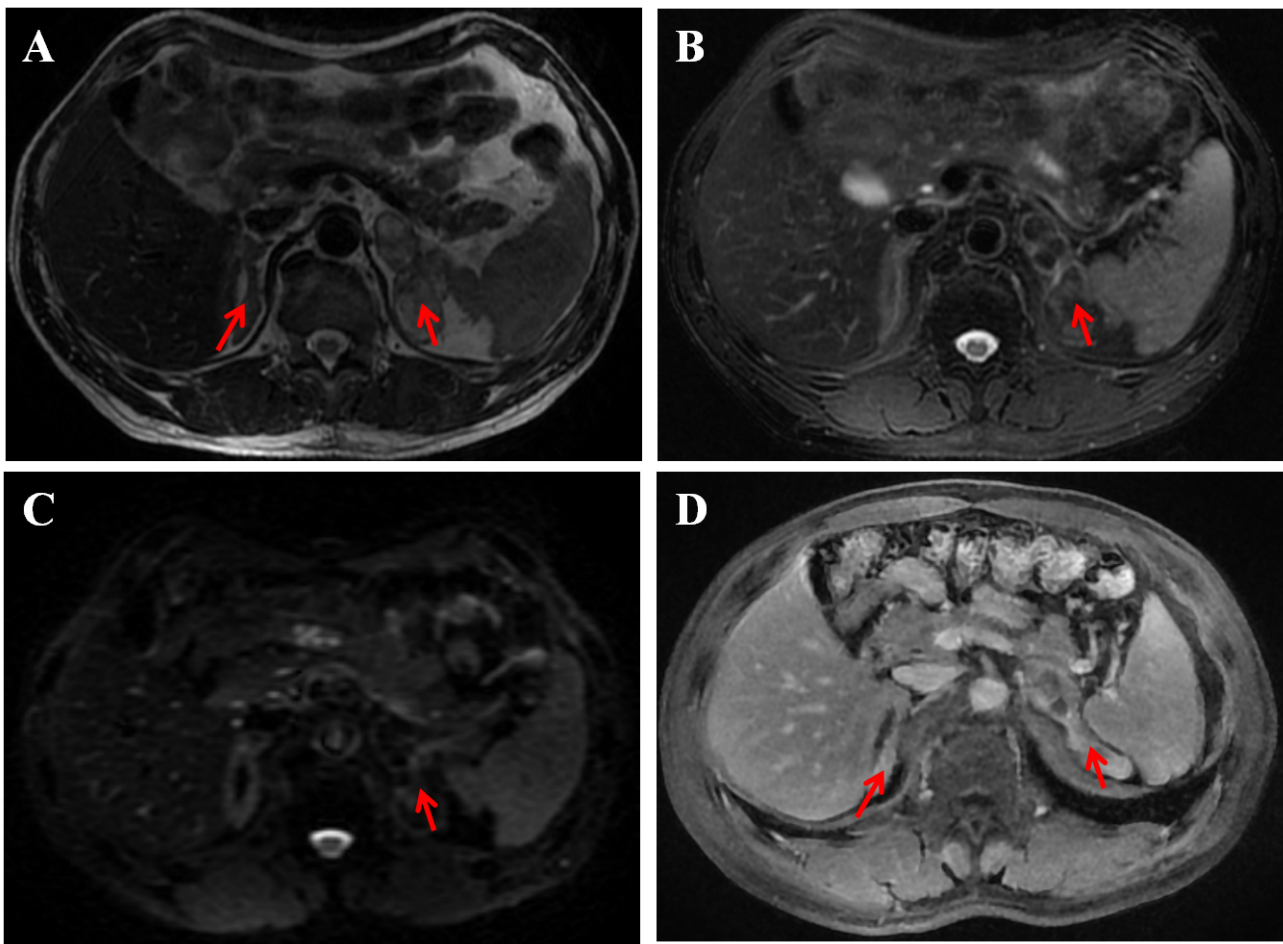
Enhanced magnetic resonance imaging of the adrenal gland. The report of the patient indicated multiple medullary lipomas within the inner and outer limbs of the left adrenal gland, an adenoma in the outer limb of the same gland, and thickening of the right adrenal gland, which is suggestive of adrenal hyperplasia. (A) On T2-weighted imaging (T2WI), the right adrenal gland is thickened and multiple abnormal masses in the left adrenal gland showed high signal intensity (the red arrows). (B) On the T2WI fat-saturated sequence, the left adrenal masses presented low signal intensity (the red arrow). (C) The diffusion-weighted imaging (DWI) signal was not high (the red arrow). (D) After contrast enhancement, the right adrenal gland showed obvious enhancement, and the left adrenal gland showed marginal enhancement (the red arrows).
